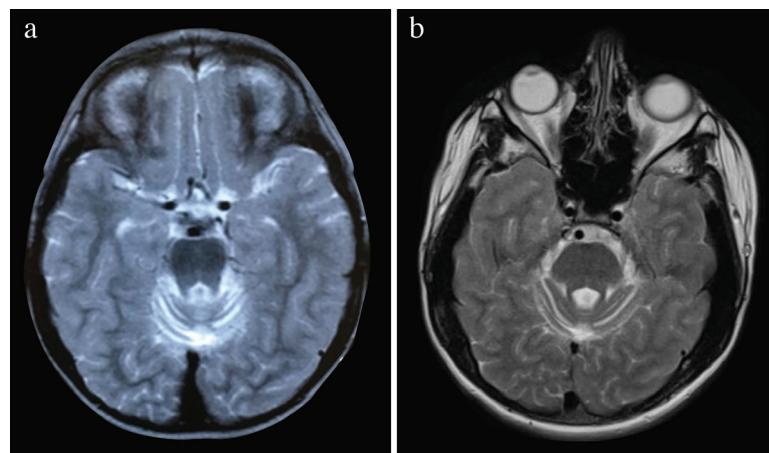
a, b. Compared to previous magnetic resonance imaging, the atrophy of the cerebellum progressed; (a) performed when he was of 3 years and (b) performed 12 years after the initial magnetic resonance imaging.
